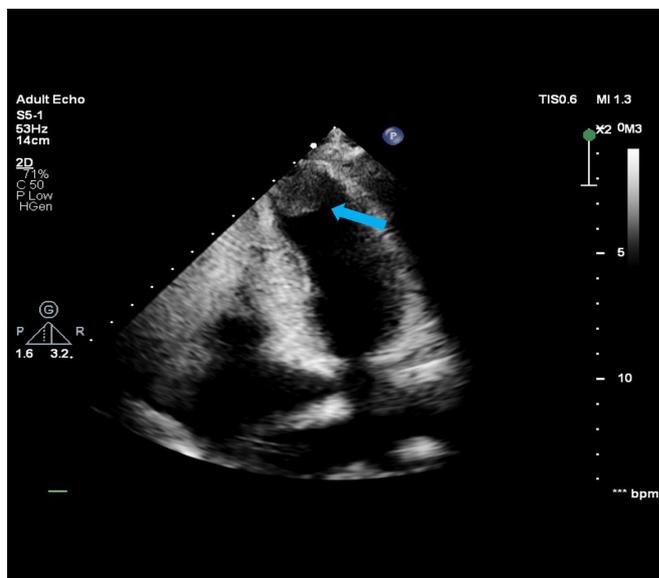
Echocardiographic examination after the biopsy revealing an echodense mass also in the left ventricular apex.
